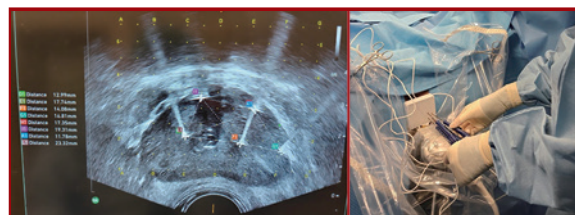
Irreversible electroporation. (Left) Transrectal ultrasound image showing the placement of five IRE electrodes around the prostate cancer lesion. (Right) Precise positioning of the probes on using a brachytherapy grid (Clinical photos from personal collection)
